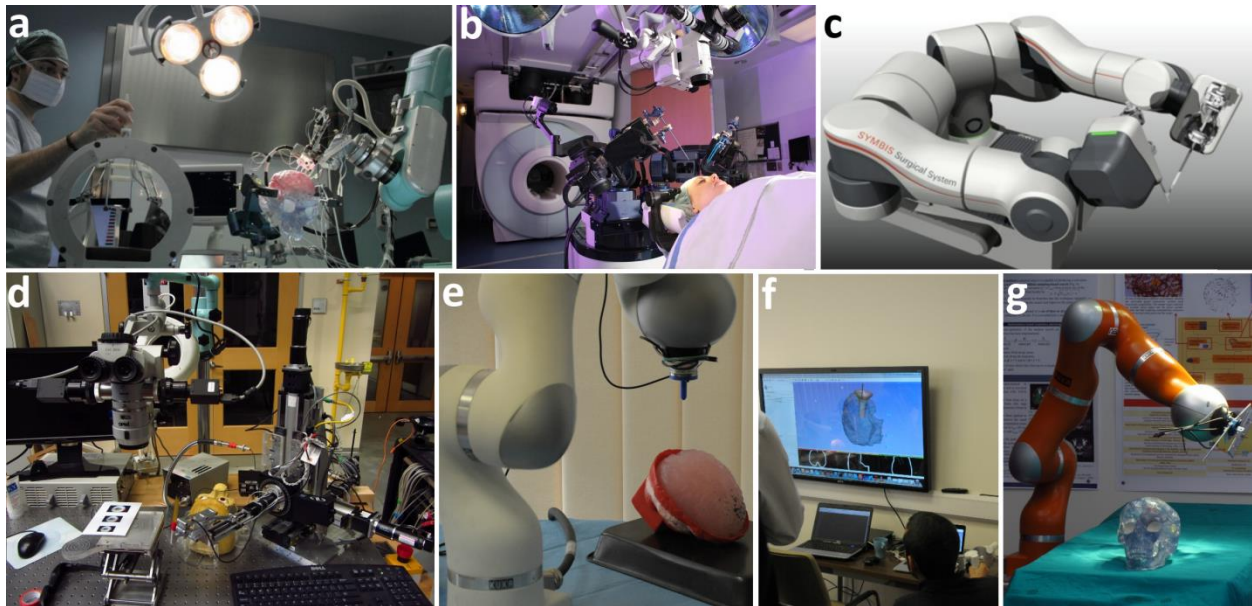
a) The final demonstration of the ROBOCAST system (Comparetti et al., 2011). b) The first clinical prototype of the MRI-compatible *neuroArm*. (Courtesy of University of Calgary.) c) Concept design for the commercial version of *neuroArm*—SYMBIS. (Courtesy of IMRIS.) d) The *Steady-Hand/Eye Robot* at JHU. (Courtesy of the Johns Hopkins University.) e–g) Experimental setups of the *ACTIVE* system (ACTIVE, 2014).
